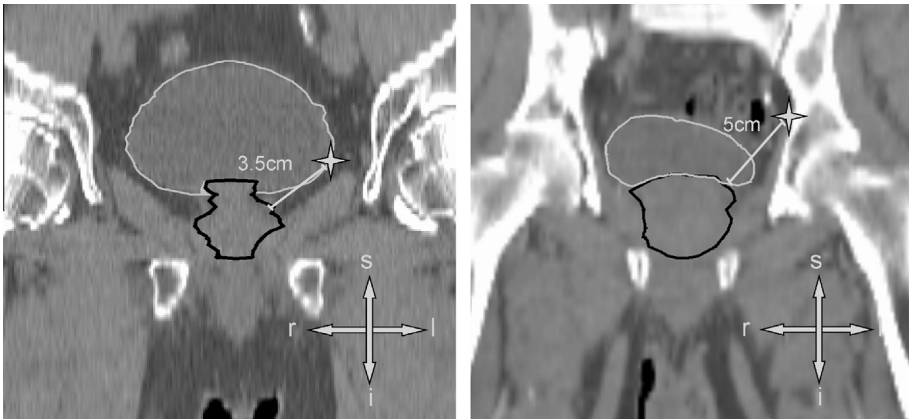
CT view of two sample patients. The star indicates the position of the two arbitrary chosen points, 3.5 cm (left) and 5 cm (right) from the prostate edge.
